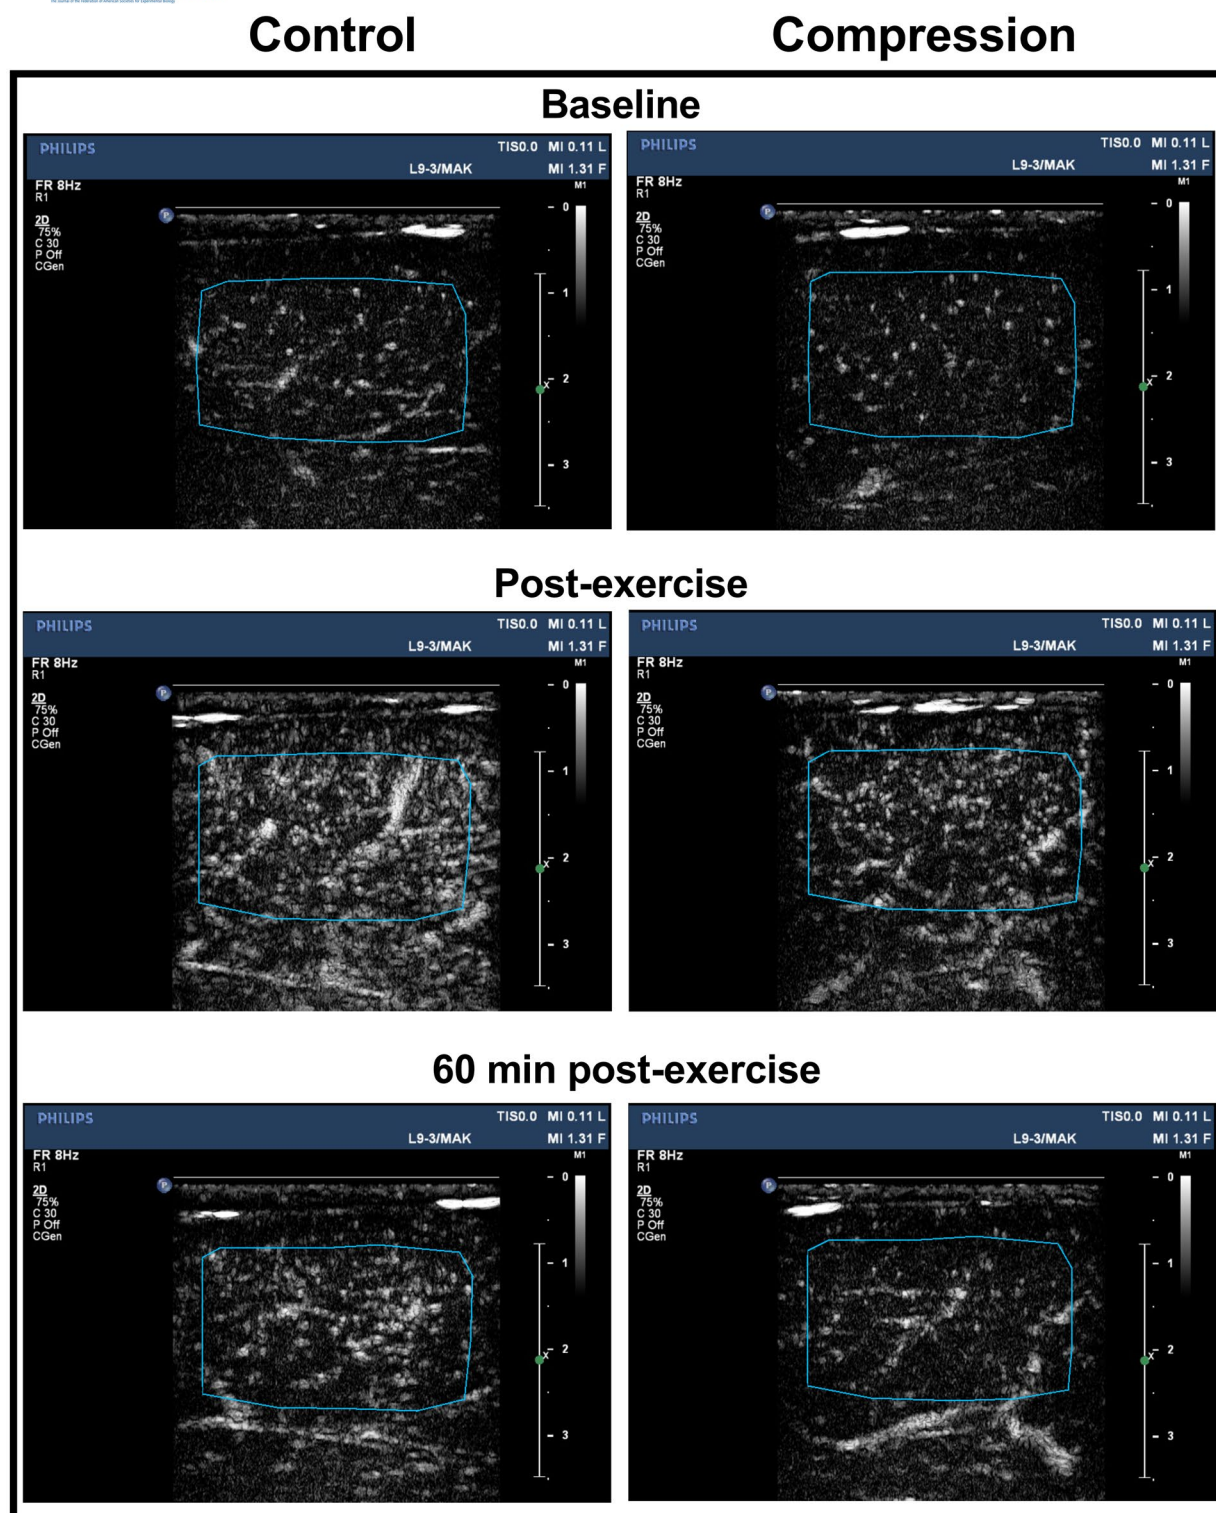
Representative contrast enhanced ultrasound images of skeletal muscle microvascular perfusion in cross-section of the Vastus Lateralis from a single participant at baseline, immediately after repeated-sprint exercise, and 60 minutes post-exercise with and without compression garments. The infused contrast agent contains echogenic microspheres which circulate within the muscle microvasculature and can be measured by contrast enhanced ultrasound. The blue box indicates the selected region of interest used to measure microspheres within the muscle microvasculature. The number of microspheres can be seen to increase after RSE with both CON and COMP and remains elevated above baseline at 60 minutes post-RSE. However, the exercise-induced increase in the number of microspheres immediately after RSE and 60 minutes post-RSE is attenuated with COMP
